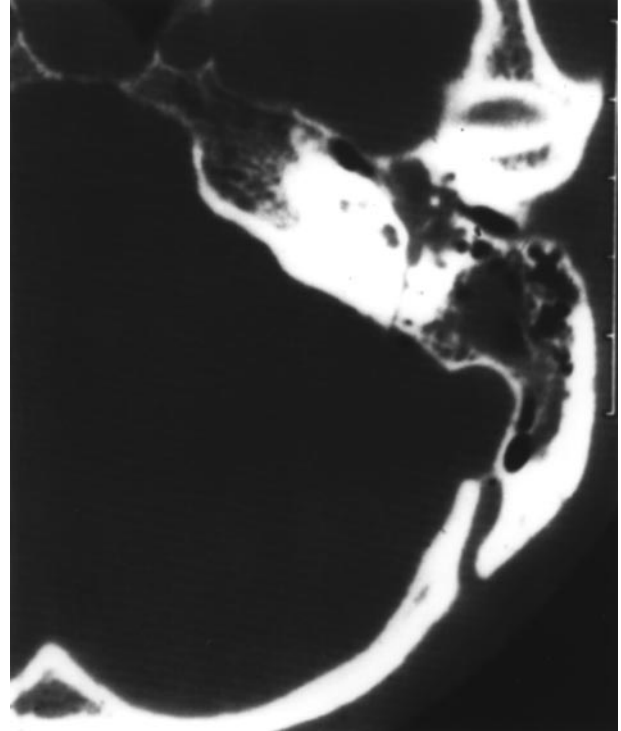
Axial computed tomographic scan with bone windows demonstrates a left longitudinal temporal bone fracture. Reproduced with permission; copyright © 1998 P. A. Wackym.
